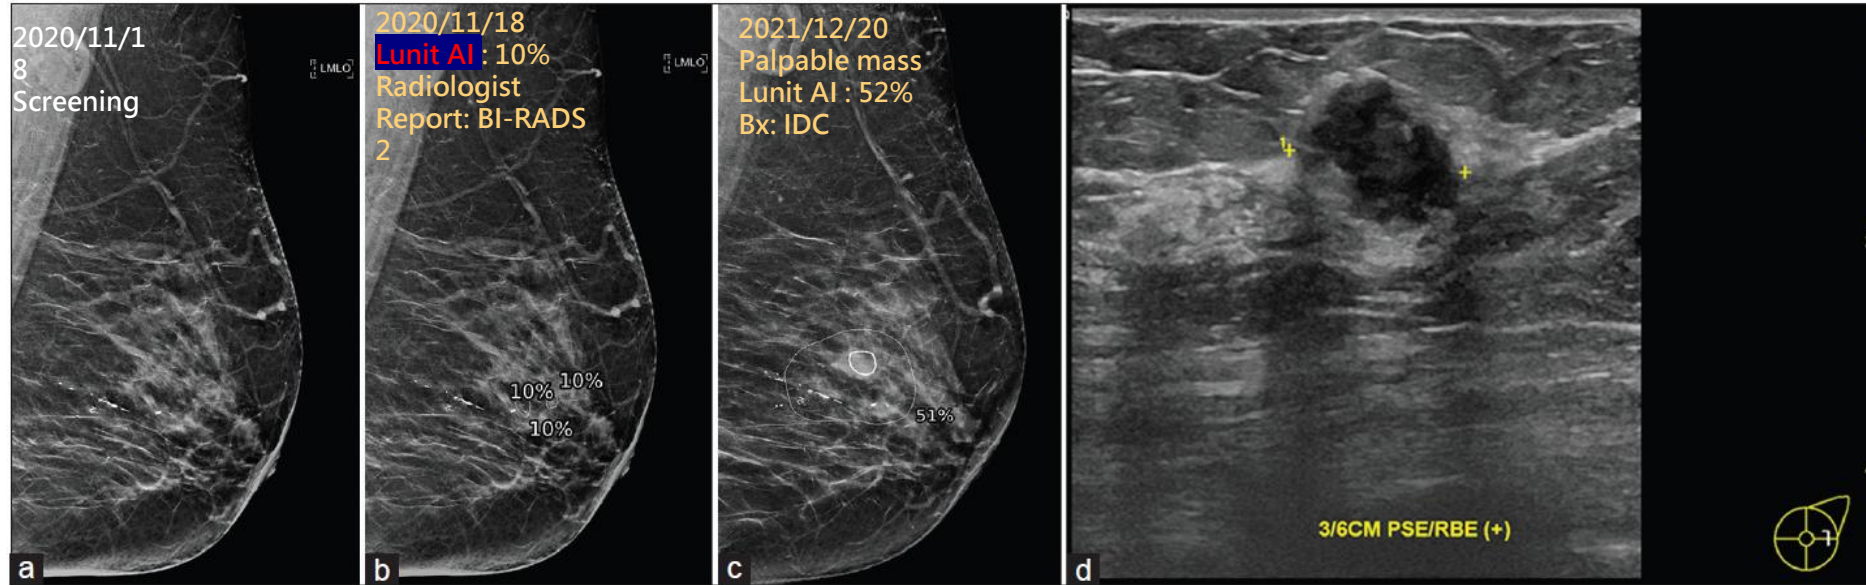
A 50-year-old woman with interval breast cancer. (a) A synthesized mammography (SM) mediolateral oblique view of the left breast assigned as breast imaging reporting and data system 2 by the radiologist at a screening examination. (b) The artificial intelligence (AI) system identified an asymmetry in the upper hemisphere of the left breast, reporting an AI-based score of 10. (c) A diagnostic SM in the subsequent year, prompted by a palpable lump, shows an irregular mass in a similar region previously pinpointed by the AI system, leading to a significantly heightened AI score of 51. (d) A targeted breast ultrasound confirmed an irregular mass
